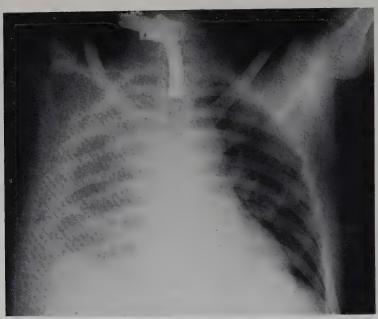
Anteroposterior roentgenogram of the chest reveals extensive fractures of the right hemithorax with a large segment of the chest wall floating. Tracheostomy tube for Moersch respirator is in place.
